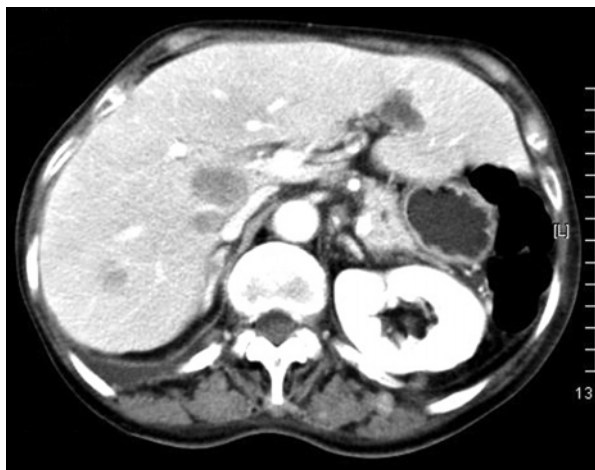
Abdominal pelvic CT. This shows multiple liver metastasis and adrenal metastasis.
